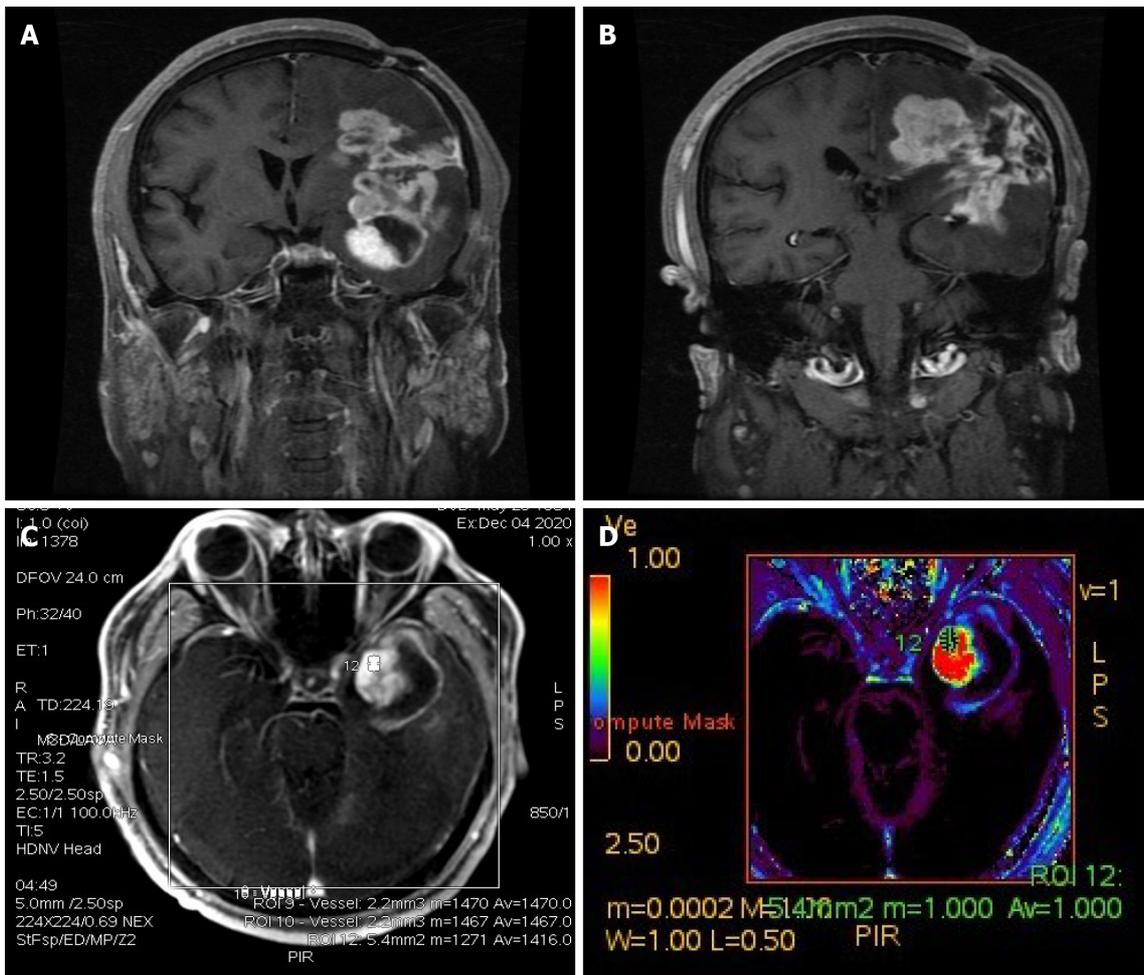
Imaging changes during patient follow-up. A and B: Enhanced T1-weighted imaging 16 mo after craniotomy indicated enlargement of the lesion; C and D: Perfusion-weighted imaging of the enlarged part of the lesion (area marked by 12 in C) suggested that the enlarged lesion had high perfusion, and tumor recurrence was considered.
